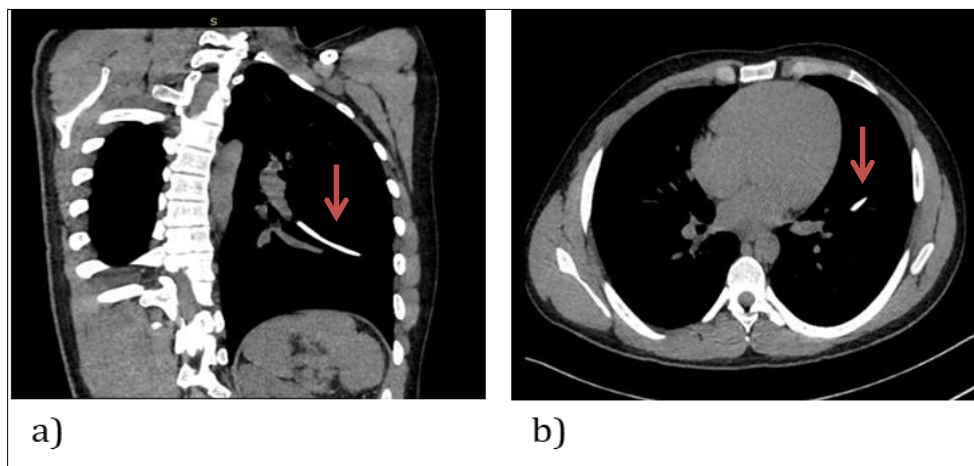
Arrows showed the location of the migrated catheter fragment in sagittal plane (a) and axial plane (b) in computed tomography
